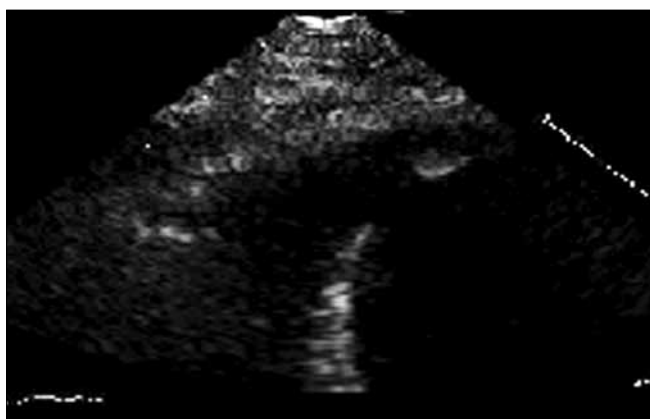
Echocardiography in apical four chamber view single and discrete muscular septal defect
